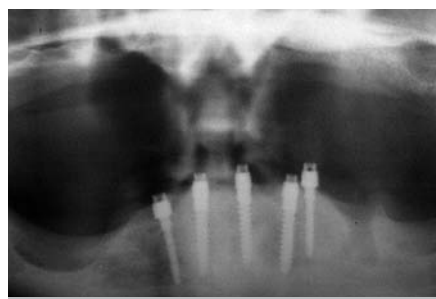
Radiograph of the placed implants.
